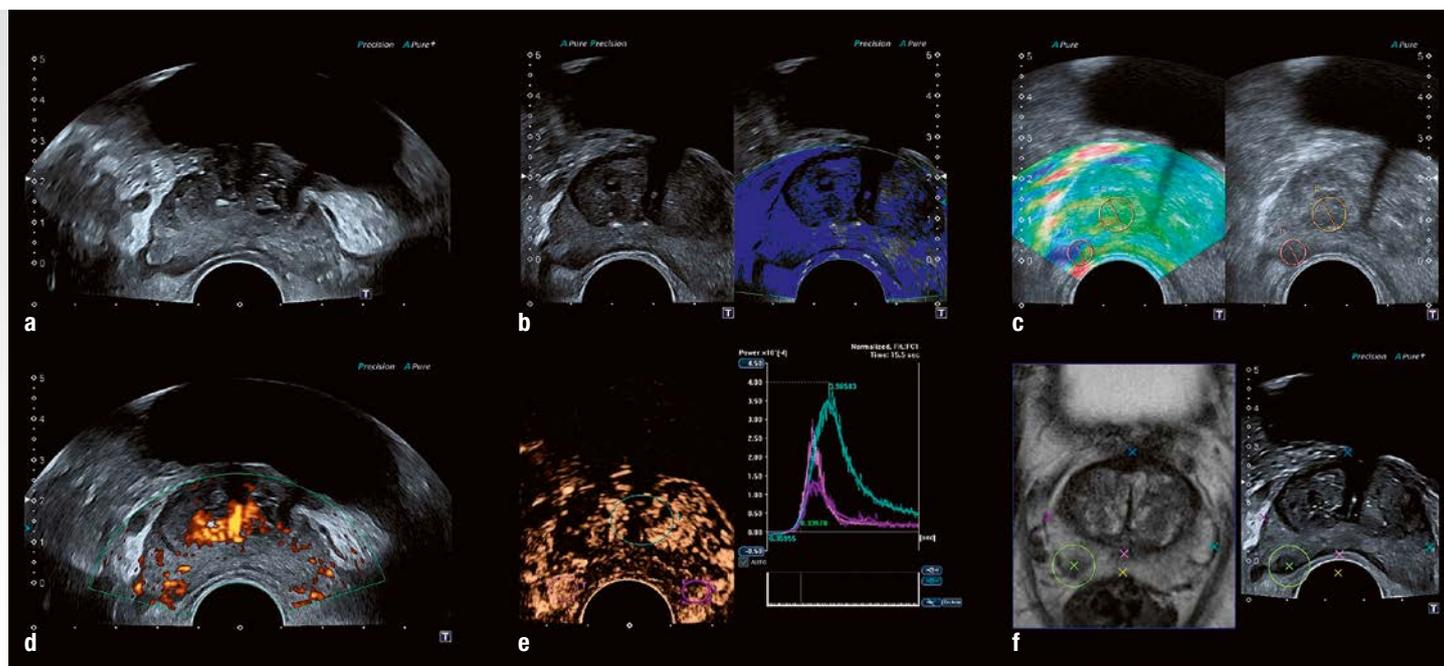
(a–f): Example of the mpUS scoring system: 2 points in B-mode (a), 3 points in TDI or strain elastography (b & c) based on significant stiffness, 3 points in power Doppler (d) due to high vascularization and 2 points in CEUS (e) based on perfusion information. These results translated into a high mpUS score which indicated a clinically significant PCa. In this particular case MR/US fusion-guided biopsy into the marked region (f) yielded a high-grade Gleason of 4+4=8.
